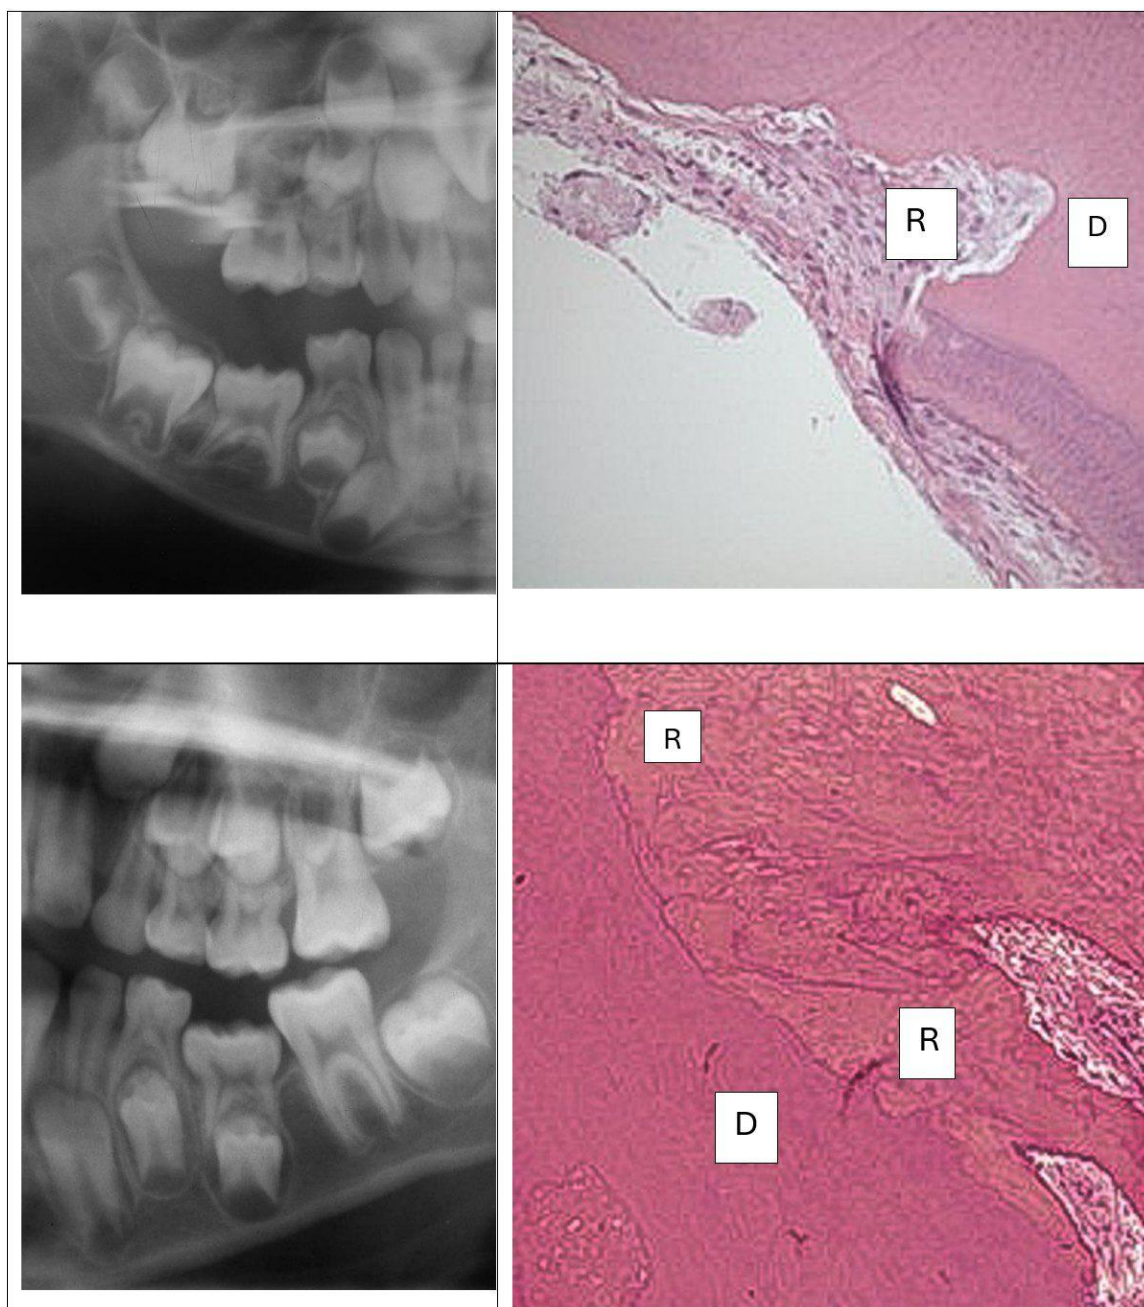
Upper. Overview of the radiographic and histochemical appearance of a periodontal area from a child, 4 years of age.
